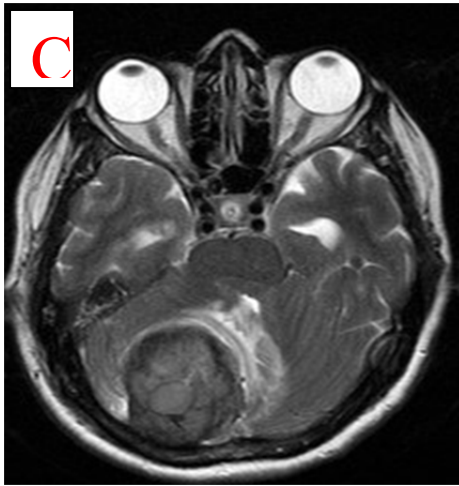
A. Yasargil type III calcified meningioma, B. T1-MRI showing hypointense T2- heterogenous hypointense lesion (C), D and E. Heterogenous contrast enhancing AXIAL and CORONAL MRI. F. MRV Showing obliteration of right transverse sinus, G. Showing post-op CT- scan showing right paramedian suboccipital craniectomy defect.
